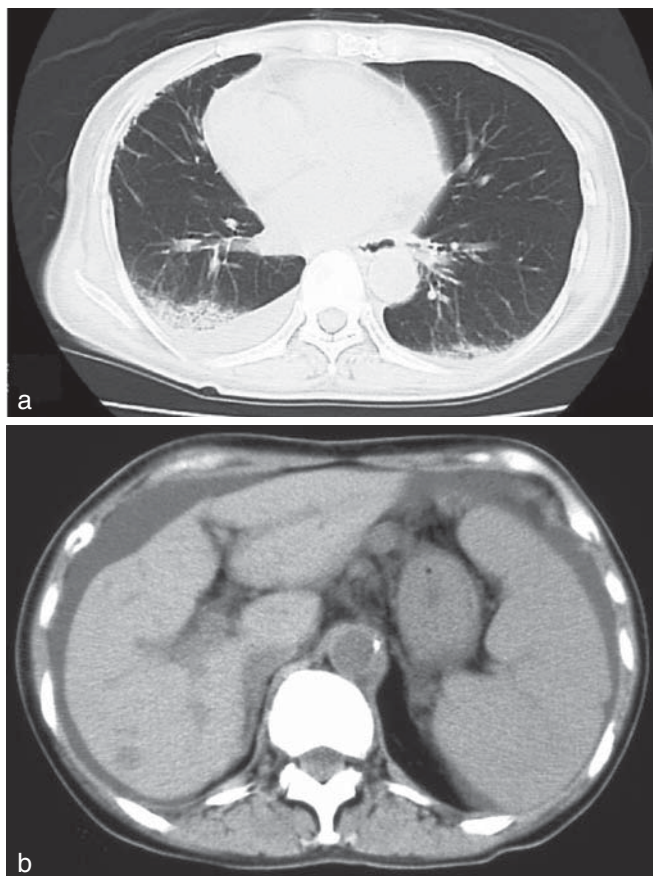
a Computed tomography of the chest. Fibrosis can be observed in the lower lobes of both lungs as well as bilateral pleural effusion. b Abdominal computed tomography findings. The liver is irregular and distorted, the spleen is enlarged, and ascites can be seen
